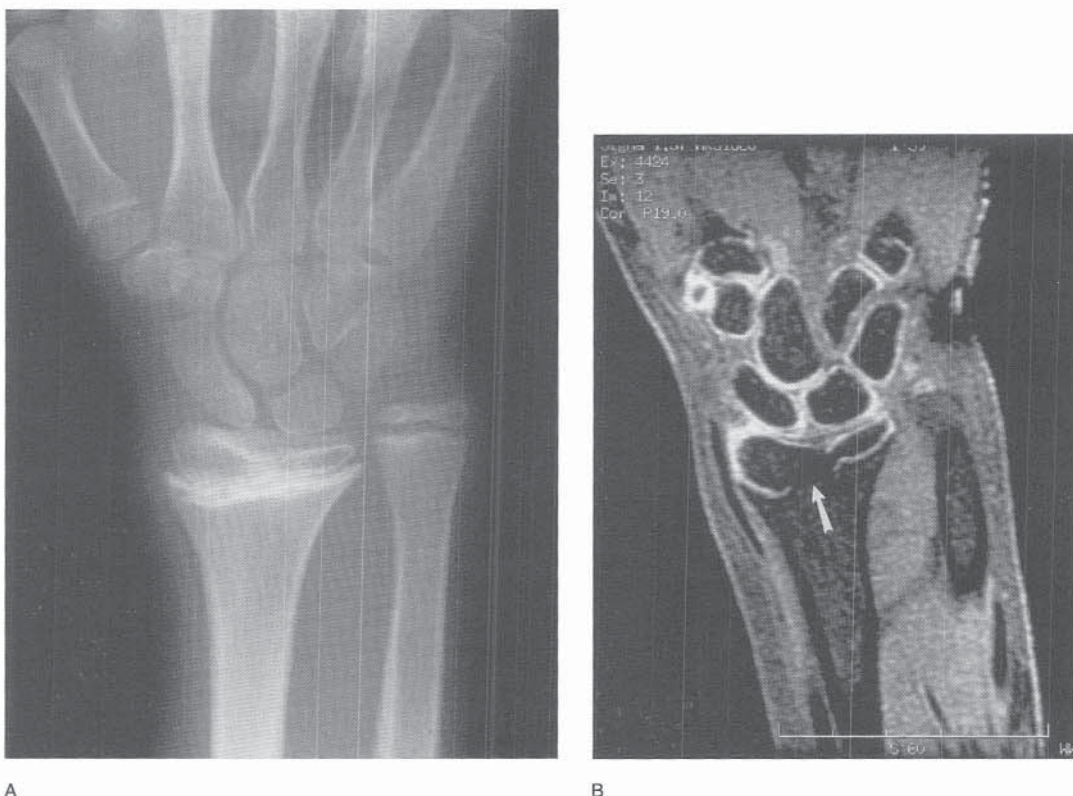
Imaging findings several months following trauma. Imaging was performed to address the clinical question of partial closure of the distal radial growth plate. A, PA radiograph of the wrist showed slight narrowing of the central portion of the distal radial growth plate and increased density of the adjacent metaphysis. B, A coronal fat-saturated spoiled gradient echo image of the wrist demonstrated loss of the increased signal intensity of cartilage at the central portion of the growth plate (*arrow*), confirming a growth plate bar.
